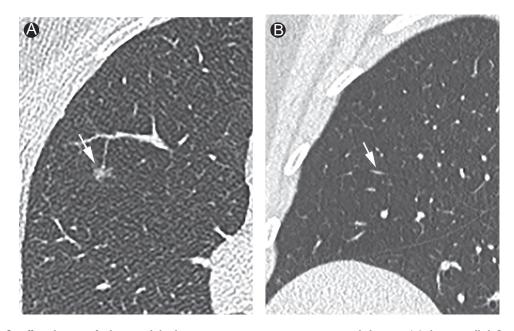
Off axial images facilitate nodule characterization. Noncontrast 1 mm axial chest CT (A) shows an ill-defined soft tissue nodule (arrow) in the anterior right middle lobe. Sagittal reformatted image (B) better localizes the nodule (arrow) to the right middle lobe, shows the nodule as abutting the right minor fissure, and demonstrates its flat shape in another (craniocaudal) dimension, favoring a benign perifissural nodule.
